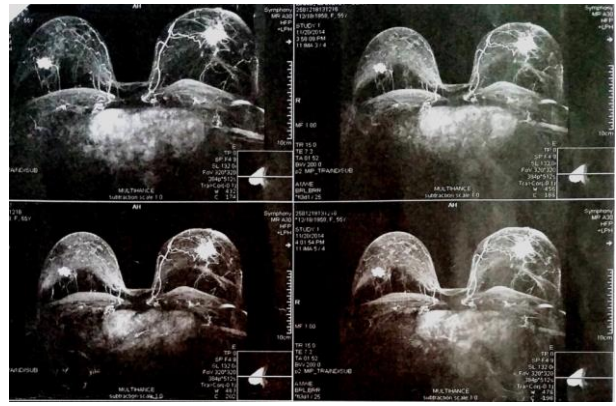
Bilateral breast MRI
